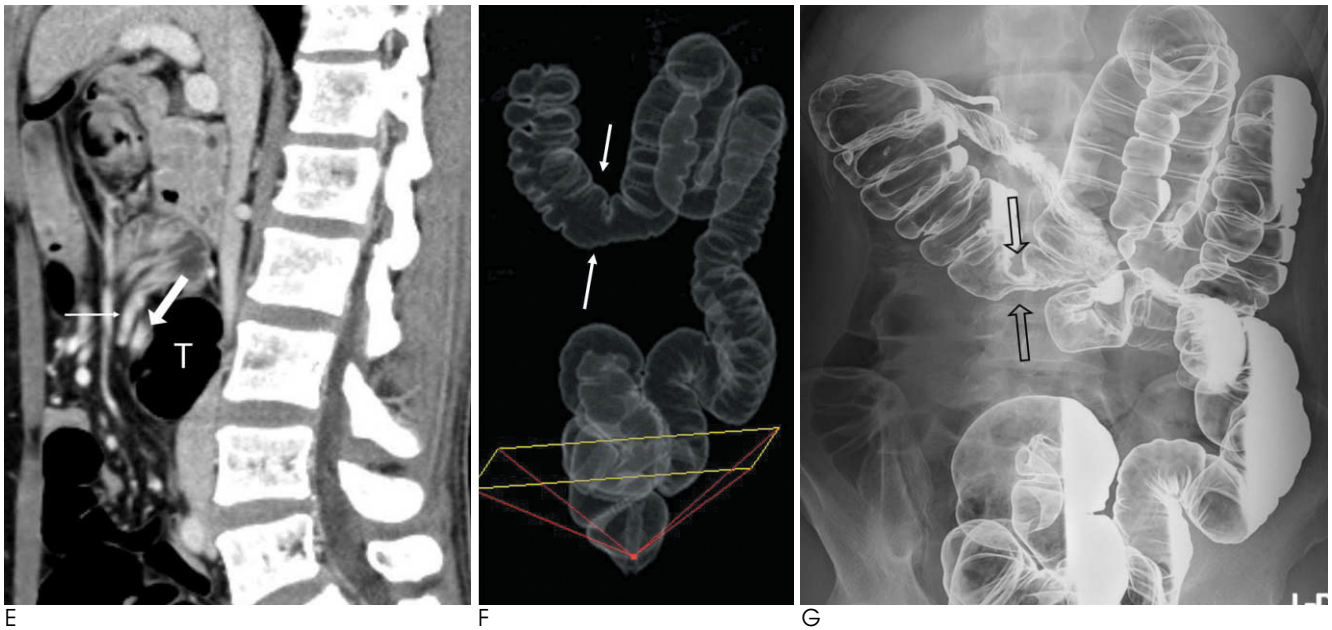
E-G. The sagittal (F) reformatted image more clearly depicted the relationship between the superior mesenteric vessels (thin and thick arrows) and the transverse colon (T). A tissue transition projection (F) from CT colonoscopy discloses focal narrowing of transverse colon (open arrows) and the abnormal location of the cecum. The overhead image after double-contrast barium enema (G) is exactly coincidental with the image of CT colonoscopy, which shows focal extrinsic compression of the transverse colon and resultant narrowing of the involved segment (open arrows). The cecum, appendix, and ileocecal valve are located in the right upper quadrant of the abdomen.
